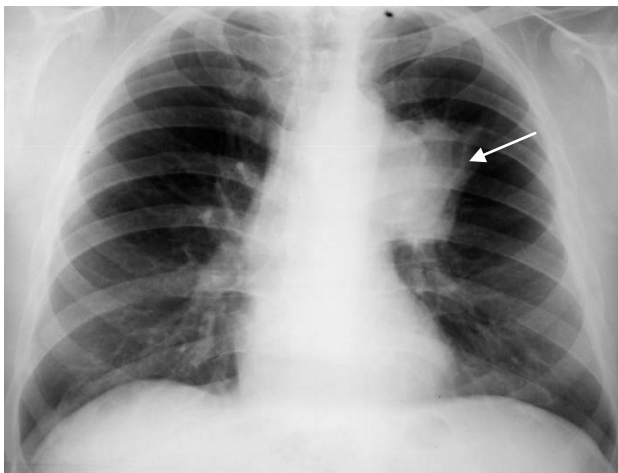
The frontal chest radiograph. Conglomerate of the increased lymph nodes in the hilum of the left lung (arrow). Mediastinal form of lung cancer in the left side
